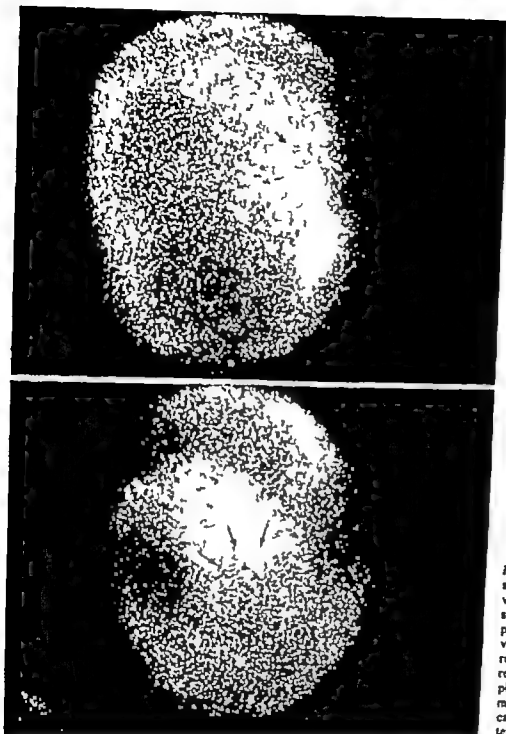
Frontal and lateral scintigrams from a patient with vaginal bleeding as only symptom. In the lateral projection there is an obvious perfusion defect (arrows) clinically corresponding to a partial placental separation. The marking on the picture indicates the position of the lateral os.
